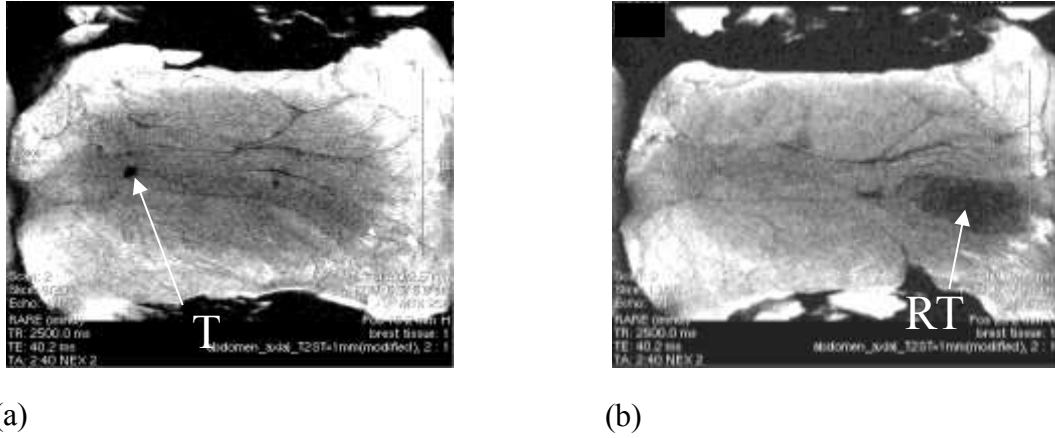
Magnetic resonance images of the left tumor and the right tumor pieces (T: left tumor, RT: right tumor)
